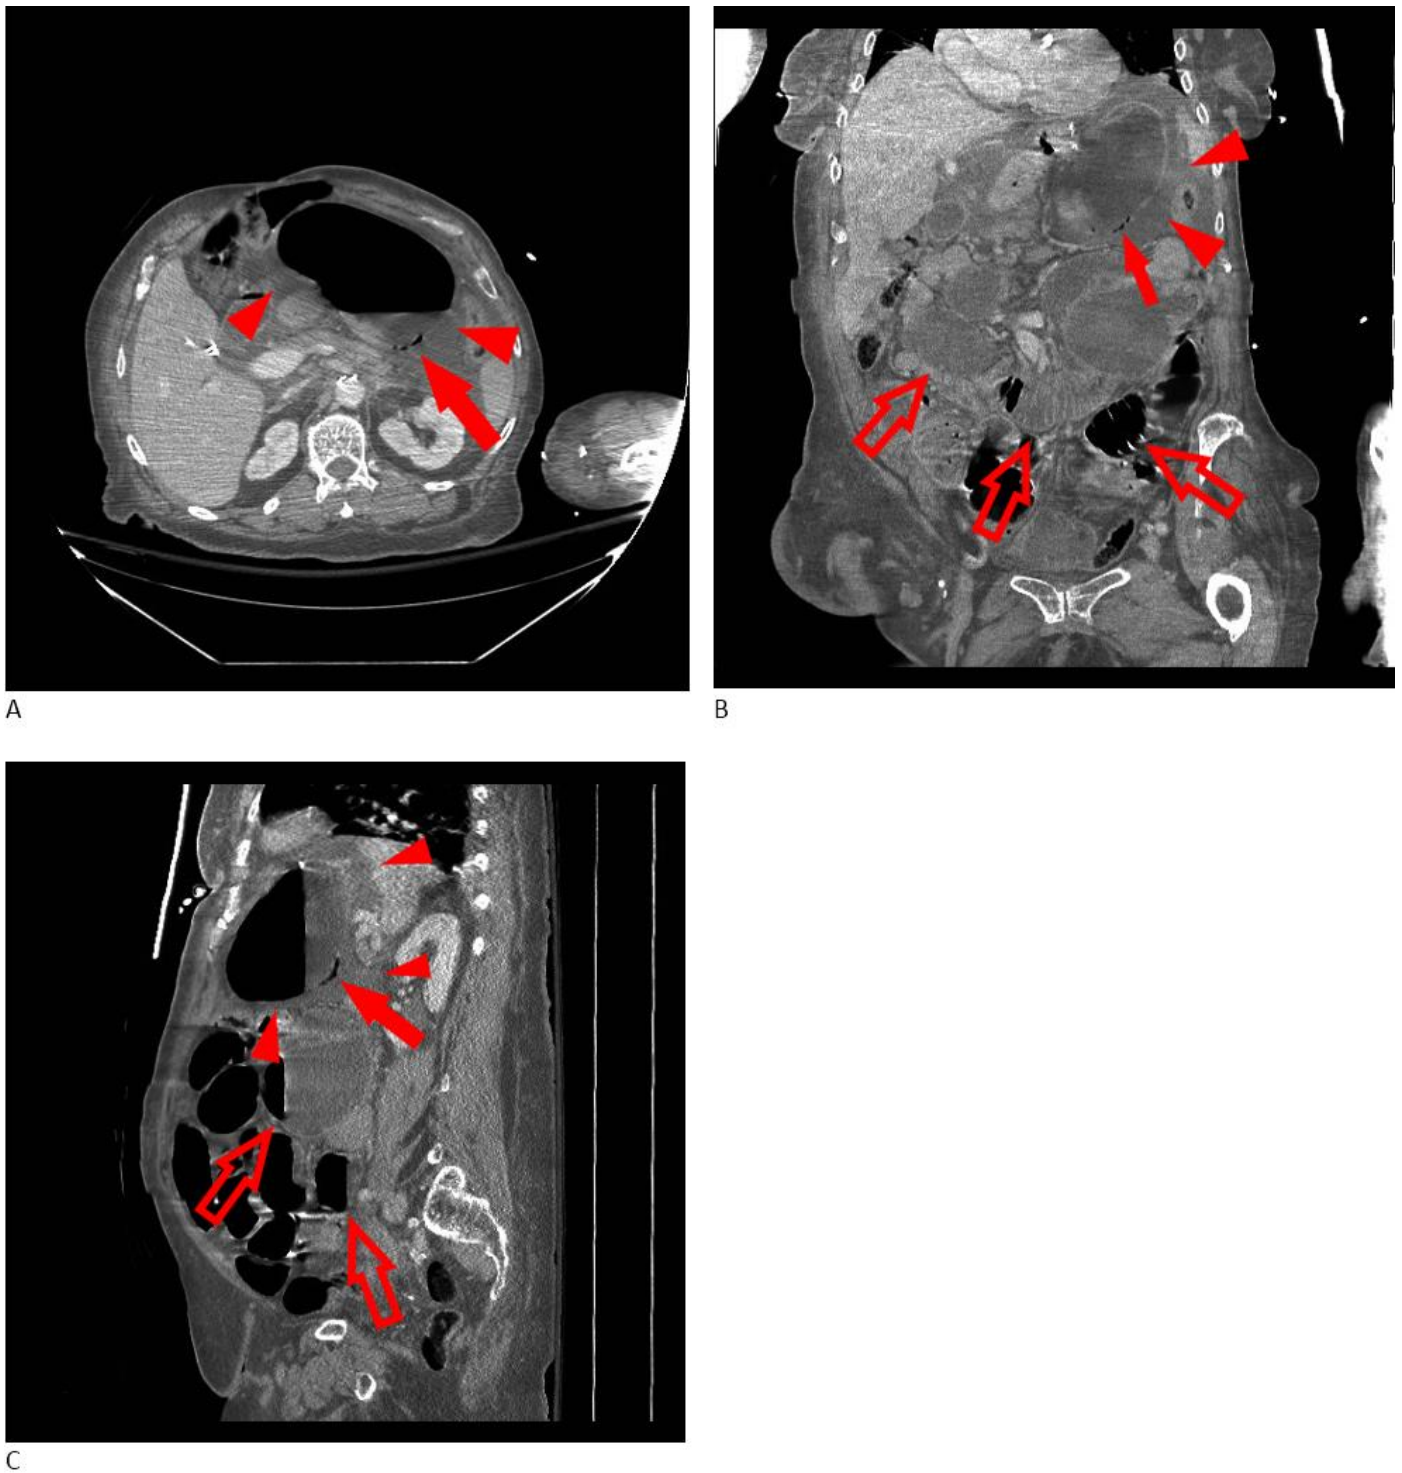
63 year old female with gastric infarction. (a) Axial contrast-enhanced CT image demonstrates a distended stomach with gastric pneumatosis (red arrow). A moderate amount of perigastric fluid is noted (red arrowheads). (b) Coronal contrast-enhanced CT image demonstrates a distended stomach with gastric pneumatosis (red arrow). Dilated small bowel loops (red open arrows), and a moderate amount of perigastric fluid (red arrowheads) are noted. (c) Sagittal contrast-enhanced CT image demonstrates a distended stomach with gastric pneumatosis (red arrow). Dilated small bowel loops with air-fluid levels (red open arrows) and a moderate amount of perigastric fluid (red arrowheads) are noted. (GE Lightspeed VCT, 120 kVp, 597 mA, 2.5 mm slice thickness, 1.375 pitch, 141 cc Omnipaque 240 IV contrast, portal venous phase)
